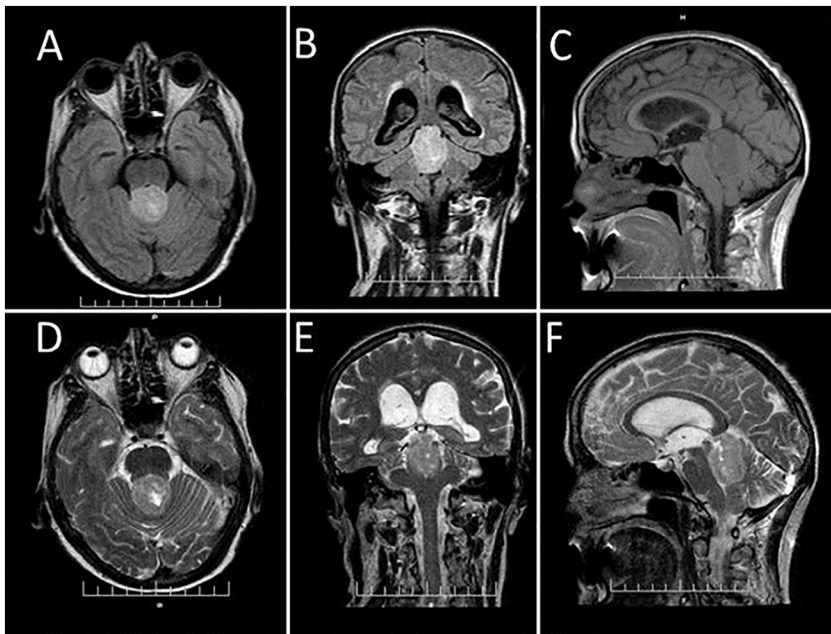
Axial (A) and (B) coronal views of Flair MRI images show a lesion located in the fourth ventricle that appears hypointense on T1 weighted MRI image (shown in Sagittal view. C). On T2 weighted MRI images the lesion reveal heterogeneous and hyperintense features (axial, coronal and sagittal view D,E,F).
